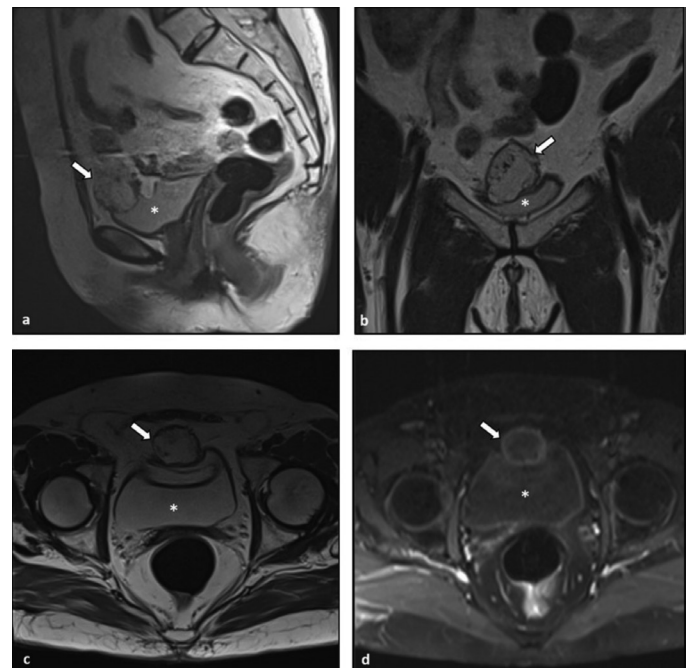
In the anterior segment of the bladder, a nodular lesion (arrows) with a diameter of approximately 35 mm is observed on T2-weighted sagittal (a), coronal (b), and axial (c) MRI as hyperintense and fat-suppressed. On T1-weighted intravenous contrast-enhanced axial MRI, the lesion appeared as a peripherally ring-enhancing hypointense nodule. Note that the lesion (*) has a similar signal intensity to the bladder
